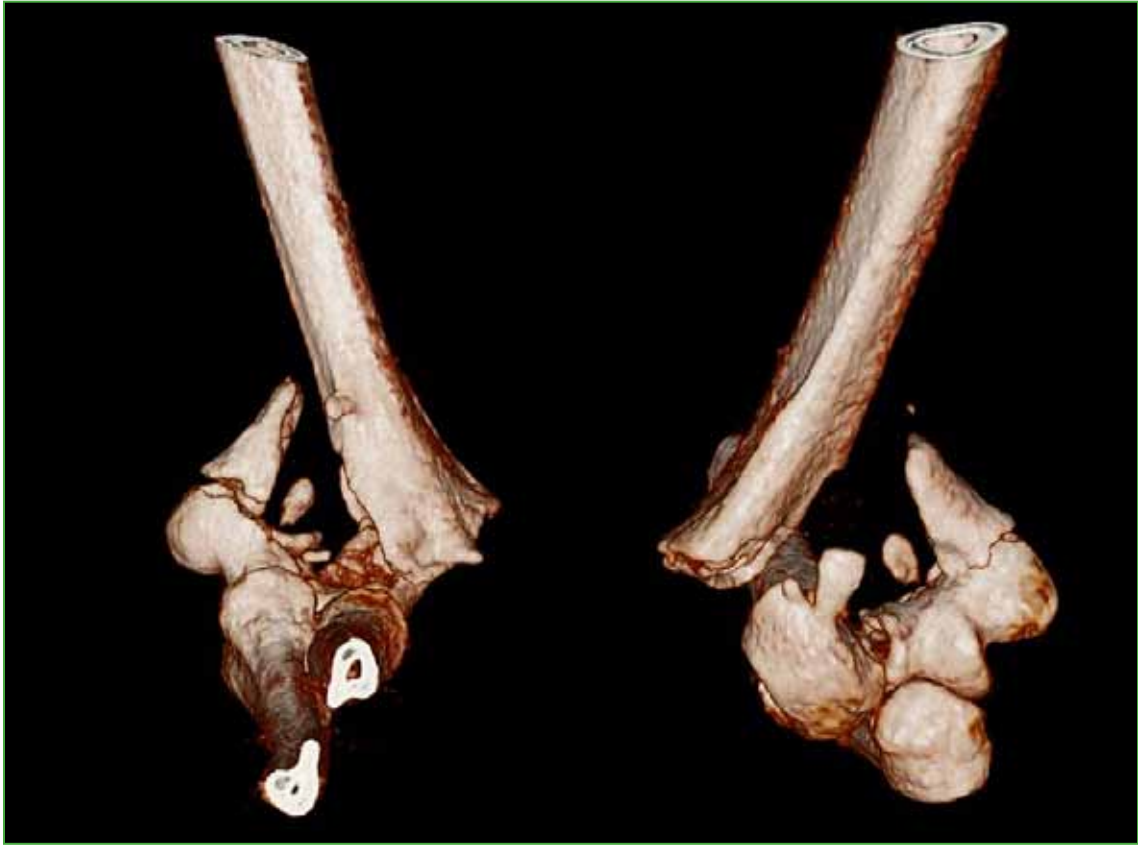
Computed tomography with three-dimensional reconstruction of an articular fracture of the distal humerus.
